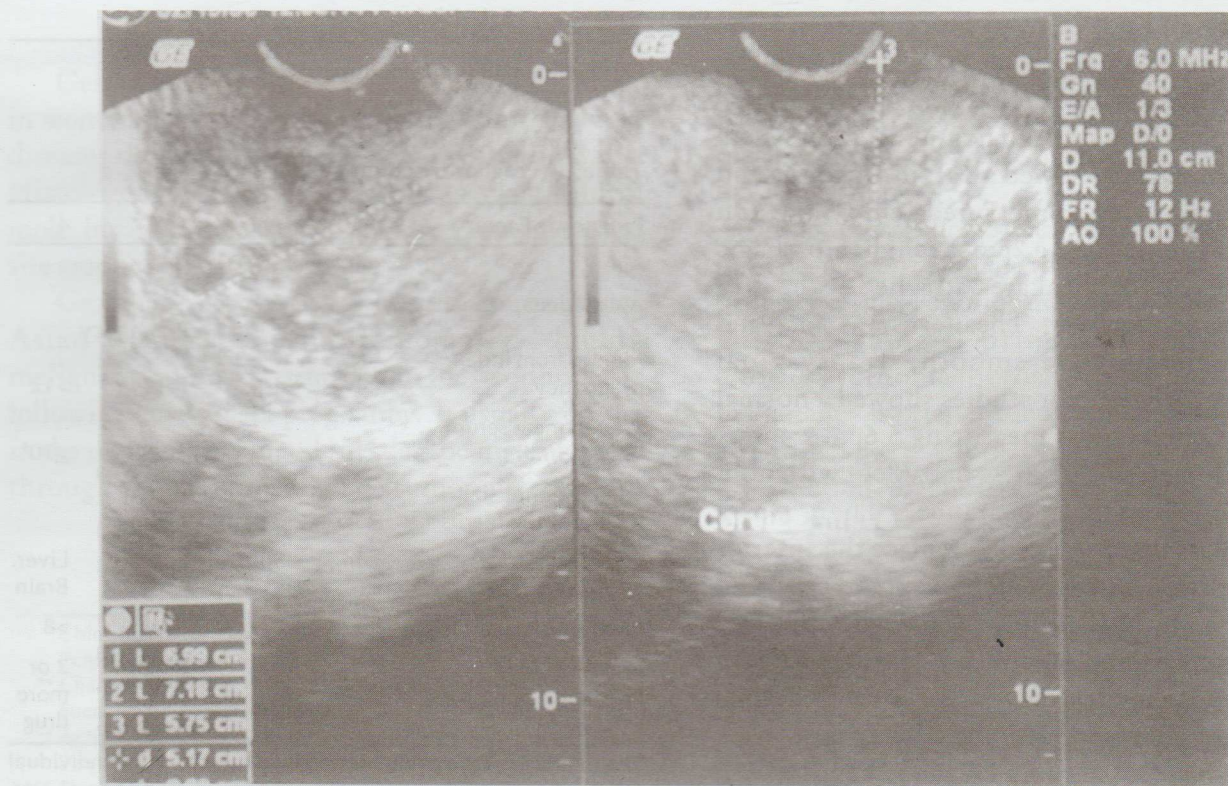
Transvaginal ultrasound of the cervical mass.
